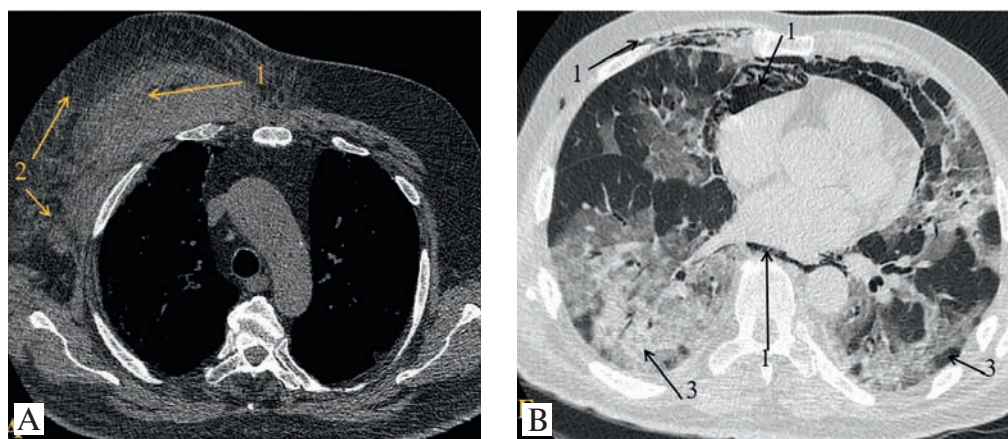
Consequences of the therapy in several patients with severe COVID-19: A, patient T. 74 years, in the intensive care unit department, mechanical ventilation in prone-position. Clinically there is a hematoma at the anterior wall of the right hemithorax. CT, axial slices, 9th day of the disease. Right thoracic muscles are increased in volume (1); stranding and oedema of the anteriolateral subcutaneous fat tissue (2); B, patient K. 74 years, in the intensive care unit department on the mechanical ventilation. CT, axial slices, 2nd day of the disease. Pneumomediastinum (1), subcutaneous emphysema (2). Subtotal increased attenuation of the lung parenchyma (3)
